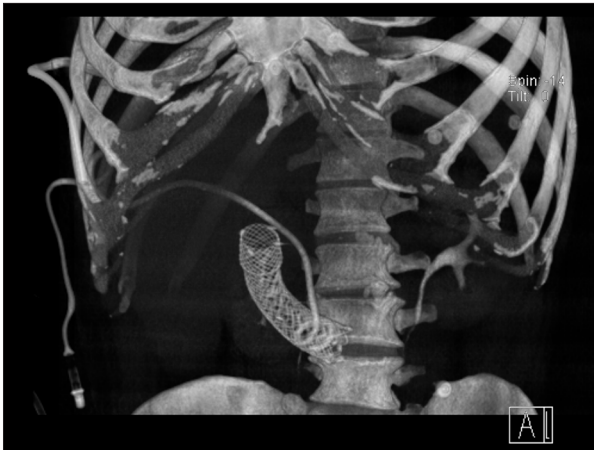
Computed tomography 3-D reconstruction demonstrating successful placement of a duodenal stent with a percutaneous transhepatic pigtail biliary drain coiled within it.
